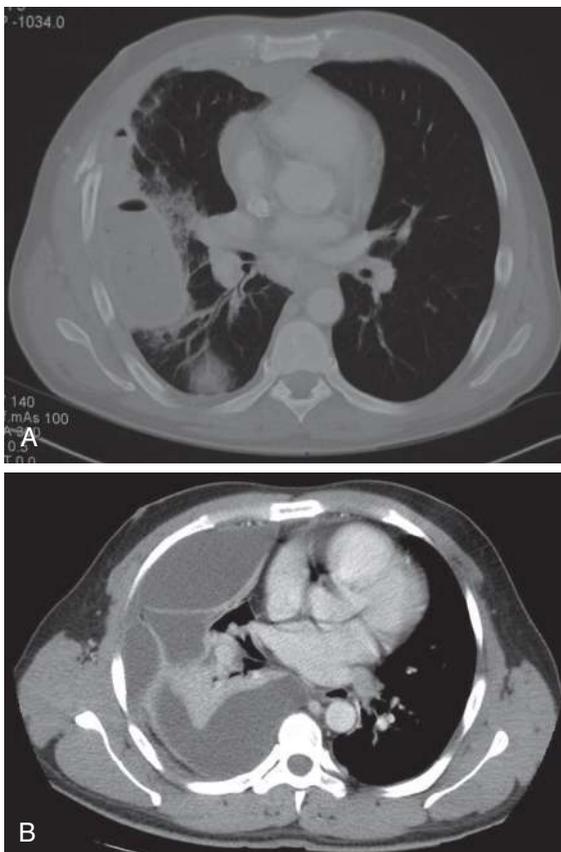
Contrast-enhanced CT scan of the chest shows (A) simple loculated effusion and (B) organized multiloculated effusion. The multiloculated effusion is unlikely to resolve with tube thoracostomy and fibrinolytics; early VATS should be considered in these scenarios.
